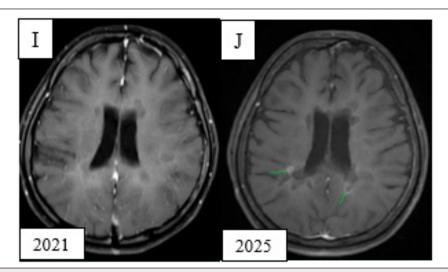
MRI Brain with contrast showed interval resolution of oedema in periventricular lesions (arrows) shown in (J) 2025 as compared to (I) 2021 (Case 1).
